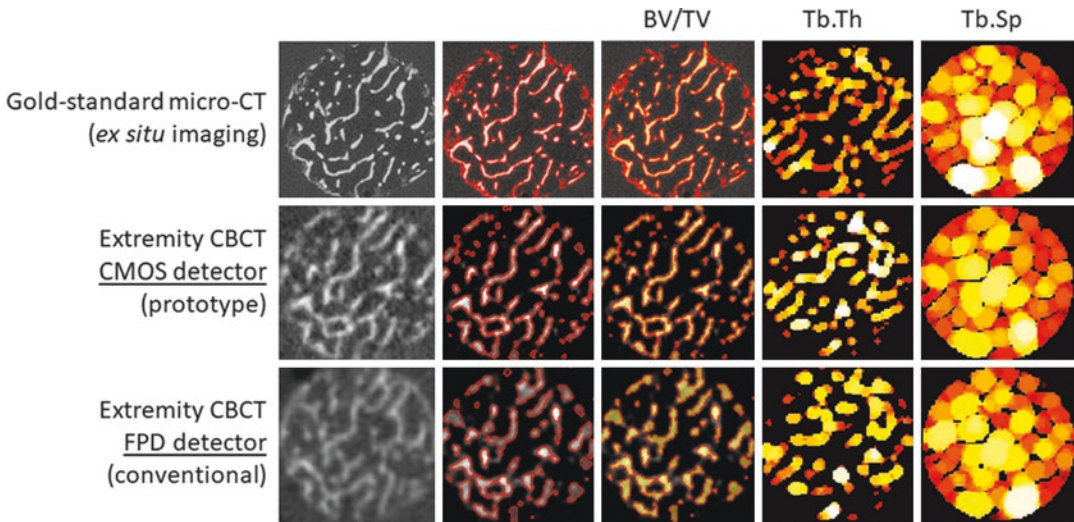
The application of a CMOS detector in a prototype high-resolution extremity CBCT (center row) enhanced the visualization of cancellous bone compared to conventional CBCT with an FPD detector (bottom row). This enabled more accurate segmentation of the trabeculae
